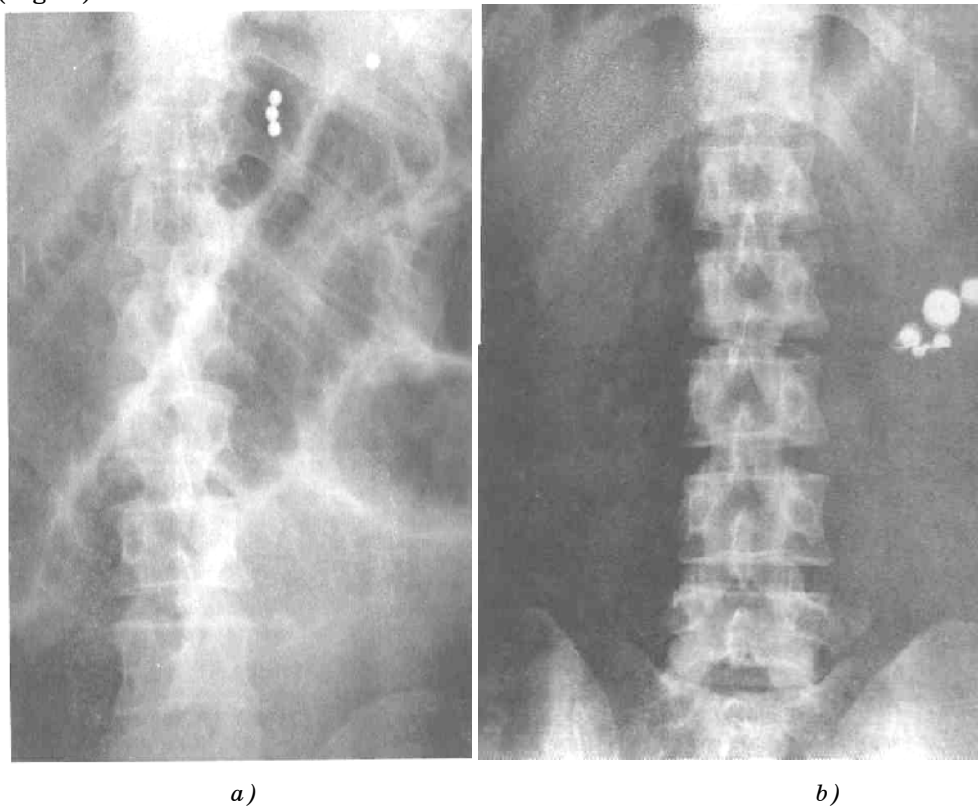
X-ray contrast marks method
